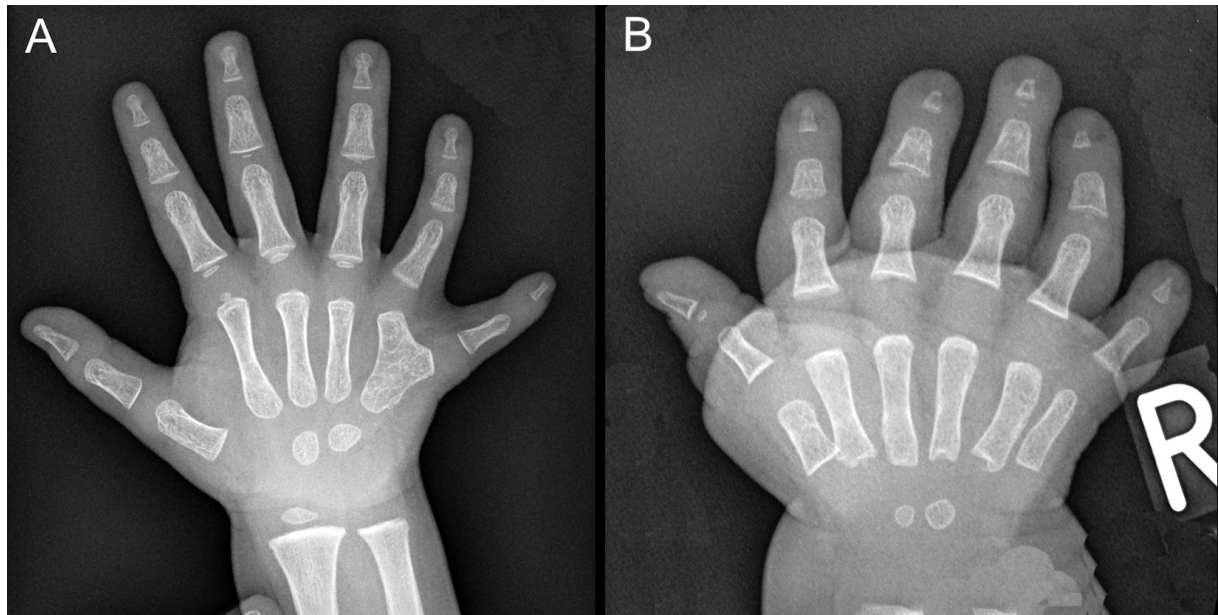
(A) X-ray of type A ulnar polydactyly with duplication at the MCP level. (B) Type A ulnar polydactyly with two complete rays (4B) (Figures: Hand surgery, Children's Hospital Wilhelmstift, Hamburg, Germany)
